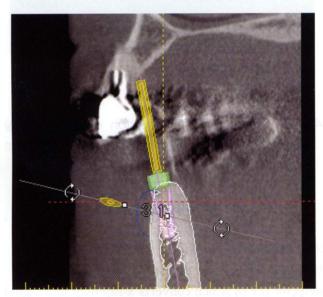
CT image to determine implant placement position and bone graft volume
